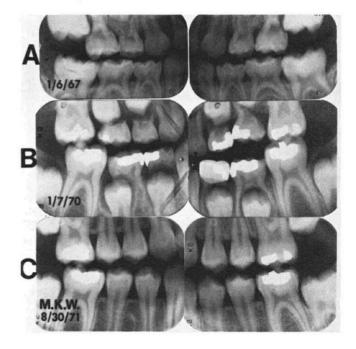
A series of bitewing radiographs of a Caucasian female showing progression of primary molar ankylosis. (A) Note slight infraocclusion of mandibular first primary molars and ectopic eruption of the maxillary left first permanent molar. (B) Note loosening of mandibular first primary molars, moderate infraocclusion of the mandibular second primary molars with an unequal resorption pattern of the roots of the mandibular right second primary molar, and moderate infraocclusion of the maxillary left second primary molar. (C) All bicuspids are fully erupted. Note the residual primary molar root fragment mesial to the mandibular right second bicuspid. affected in 35 dentitions (33%). Pattern III comprised multiple ankylosed molars ranging from three to seven affected teeth (24 dentitions, or 22%). This pattern was viewed as a combination of one, two, or three molar pairs (as Pattern I), plus one or more single occurrences in any quadrant.
